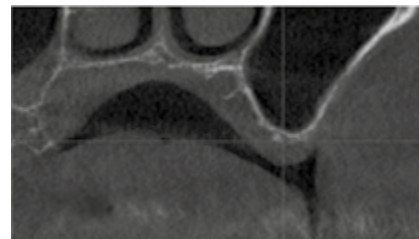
CBCT seno mascellare sinistro.
